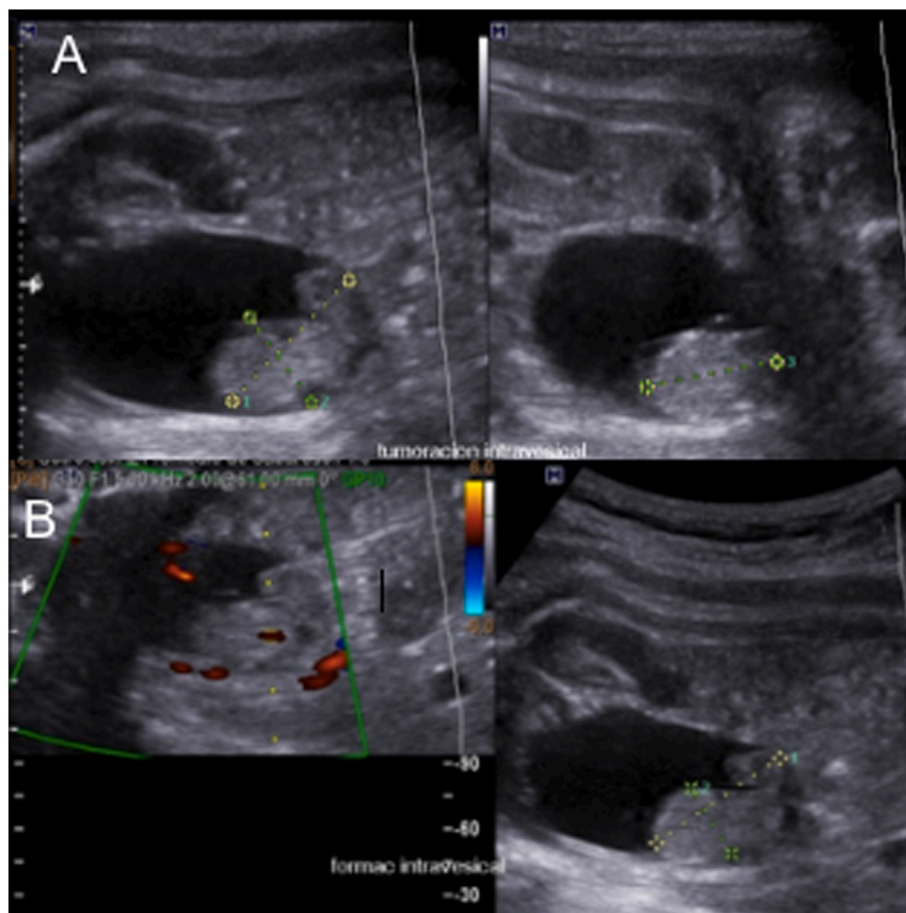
Pre-natal ultrasound (A) Display a bladder tumor. (B) Vascularized lesion in doppler study.
